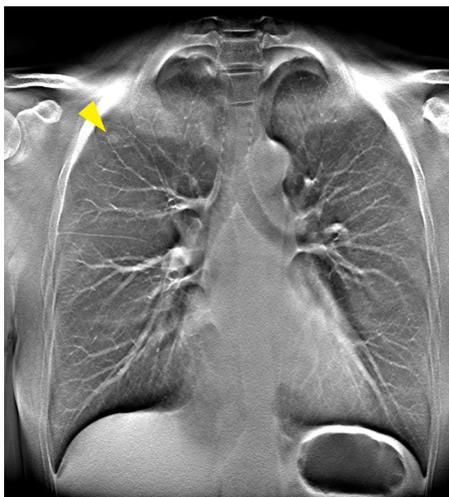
Case Where a Lesion Is Not Visible in a Plain Chest Radiograph but Is Visible Using Tomosynthesis
